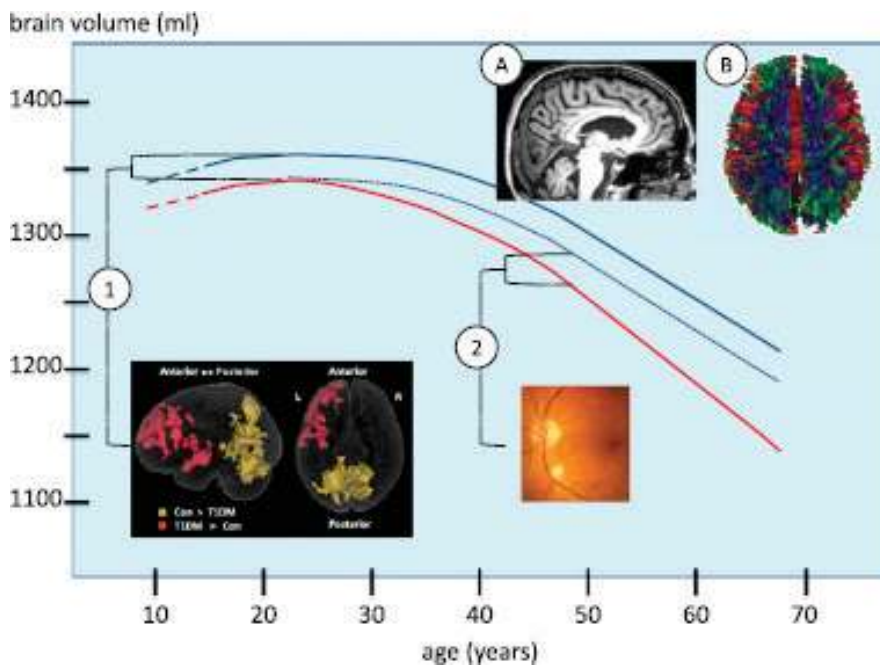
The trajectory of disorders from the brain's magnetic resonance imaging data in patients with type 1 diabetes mellitus is associated with loss of brain volume (blue line, evolution of brain volumes with age in the general population, and red line, estimated trajectories for type 1 diabetes mellitus (A), and brain atrophy is a loss of neuron communication (B)) [1].
